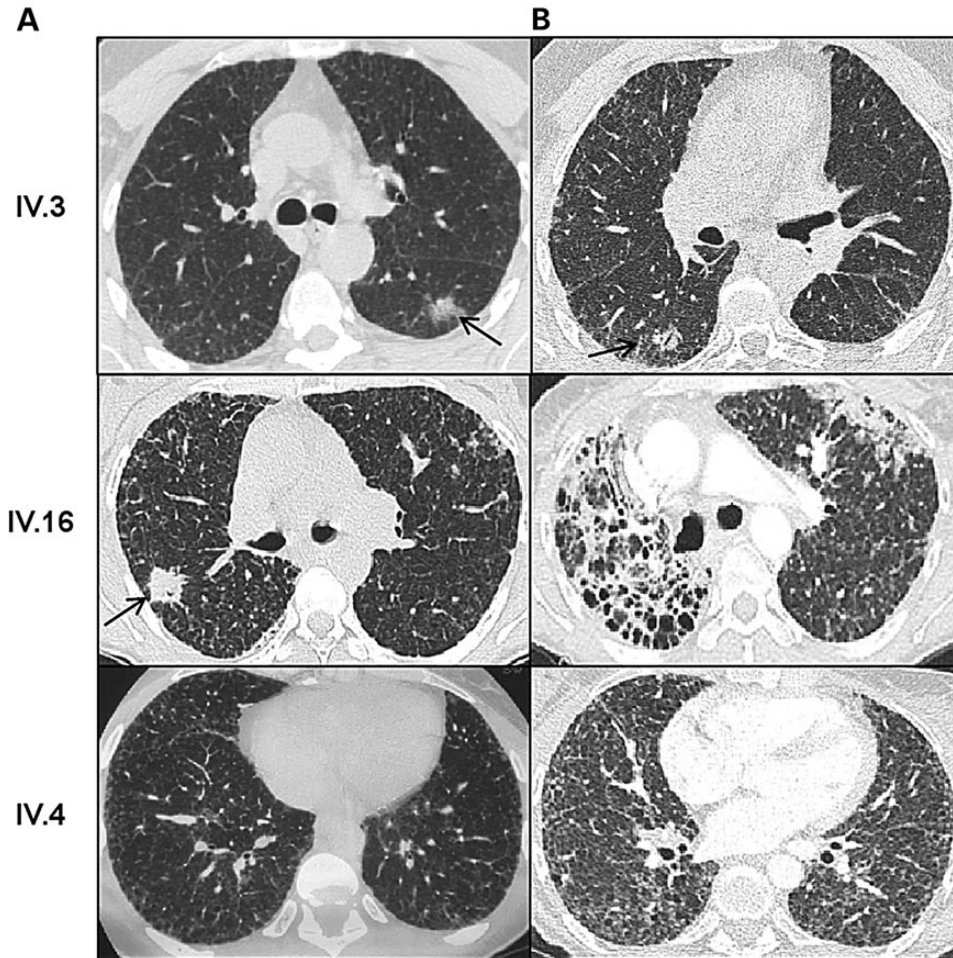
Representative thoracic HRCT scans of affected individuals carrying the SP-A1 W211R mutation. Thoracic HRCT scans of Patients IV.3, IV.16, IV.4 at diagnosis (A), and during follow-up (B). Individual IV.3 presented at age 50 with a severe fibrosing interstitial lung disease and a left lung adenocarcinoma that was surgically removed (\rightarrow) (IV.3, A). After 4 years, the patient experienced a worsening of his clinical condition that was associated on the chest HRCT scan with an extension of the lung fibrosis and an adenocarcinoma relapse located on the right lung (\rightarrow) (IV.3, B). Individual IV.16's HRCT scan at age 54 (IV.16, A) showed a severe interstitial lung disease with subpleural fibrosis, and a right adenocarcinoma (\rightarrow) that was surgically removed. After 4 years of follow-up, the chest imaging revealed a progression of the disease with an extensive and asymmetric fibrosis (IV.16, B). Individual IV.4 had a first HRCT scan at age 40, showing a mild interstitial lung disease (IV.4, A). After 18 years of follow-up, her pre-transplantation HRCT scan showed a severe diffuse fibrosis without evidence of adenocarcinoma (IV.4, B).
